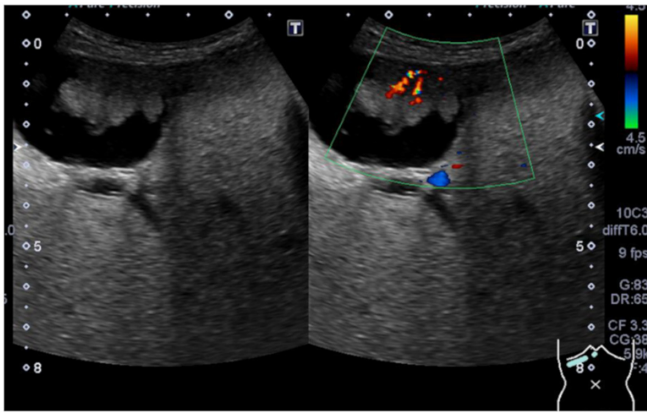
Ultrasonography revealed a cauliflower-like homogenous tumour, which was 2.7 cm at its maximum diameter, at the fundus of the gallbladder, and colour Doppler imaging showed the blood supply to the tumour.
